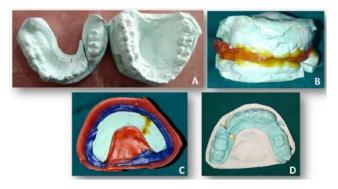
A: Cast made after taking impressions and fractured according to radiographic fracture line; B: Occlusion achieved in accordance to opposite arch; C: Rebasing under process; D: Final cast
